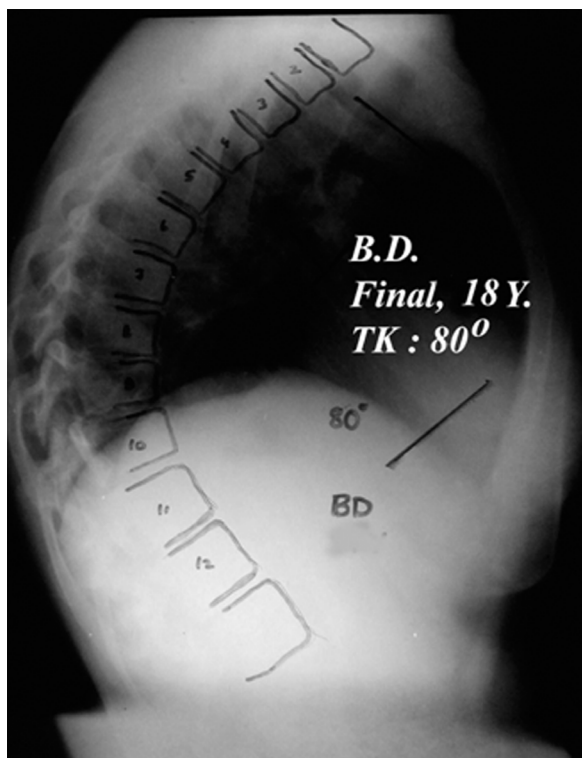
Lateral radiographies of the patient with 80° Scheuermann’s kyphosis.
